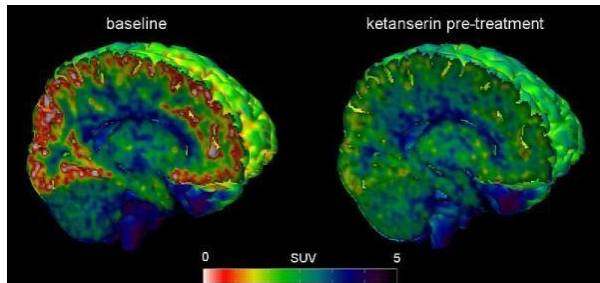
Representative PET images of cerebral [¹¹C]Cimbi-36 binding in the human brain at baseline and after ketanserin pre-treatment. PET images show radioligand uptake from 40-120 min and scaled to standardized uptake values (SUV in g/ml), and images are superimposed on a MRI template of the brain.
